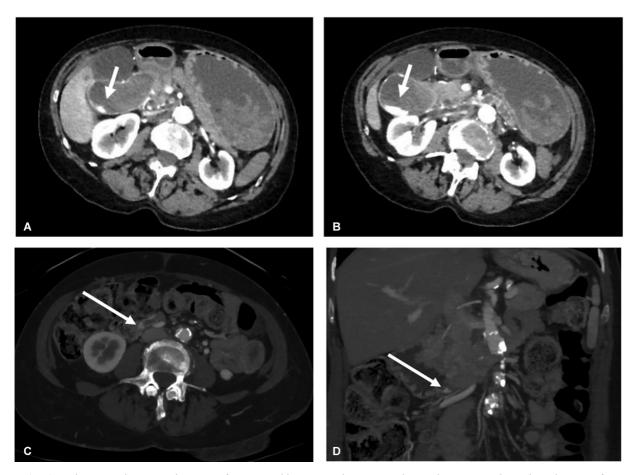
(A, B) Axial computed tomography image of a 69-year-old woman with systemic sclerosis demonstrates hyperdense layering of contrast (*white arrows*) in the proximal D1 and D2 segments of the duodenum, consistent with active gastrointestinal bleeding secondary to angioectasia. Duodenal arteriovenous malformation (*white arrows*) is visualized on (C) axial and (D) coronal MIP images (3.8 mm) obtained 3 years prior with no evidence of active extravasation. MIP, maximal intensity projection.
